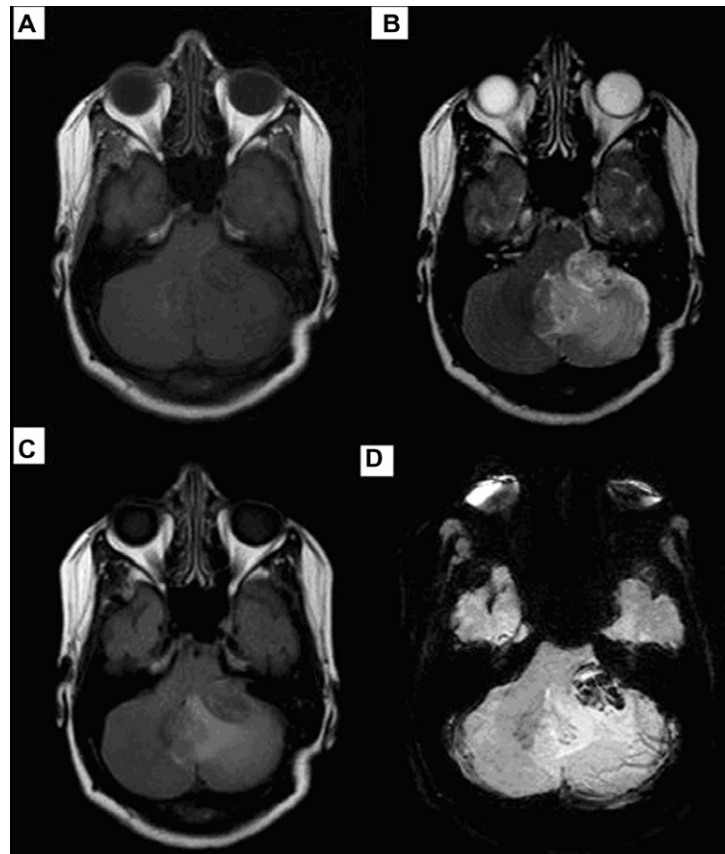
Thirty-eight year female patient presenting with bulbar symptoms. T1 (A), T2 (B) and FLAIR (C) images show left CPA angle lesion, SWI minIP (D) images clearly reveal hemorrhagic foci within the mass aiding in the diagnosis of schwannoma.
